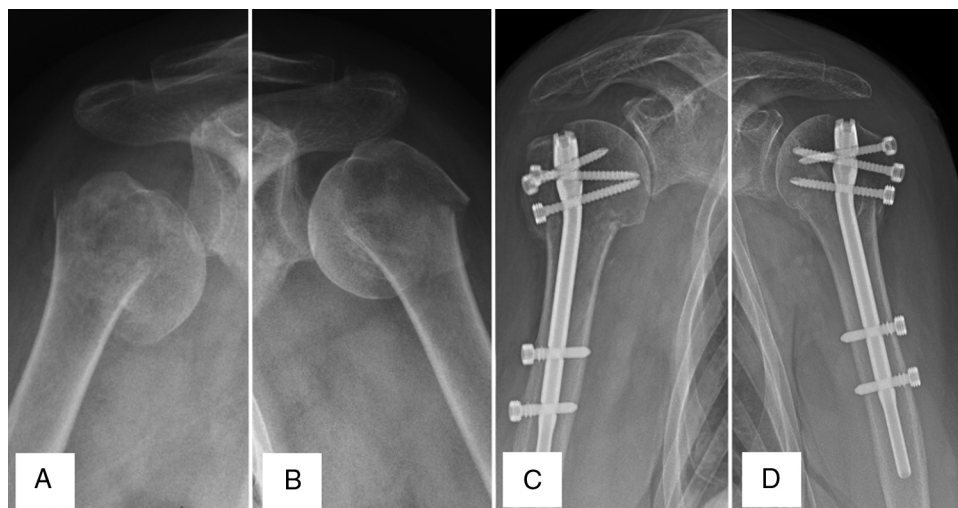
(A) Bilateral fracture of the humeral proximal extremity, deviated in varus, right shoulder; (B) left shoulder; (C) radiographs, at three months postoperatively of fixation with intramedullary nail, right shoulder; (D) left shoulder.
